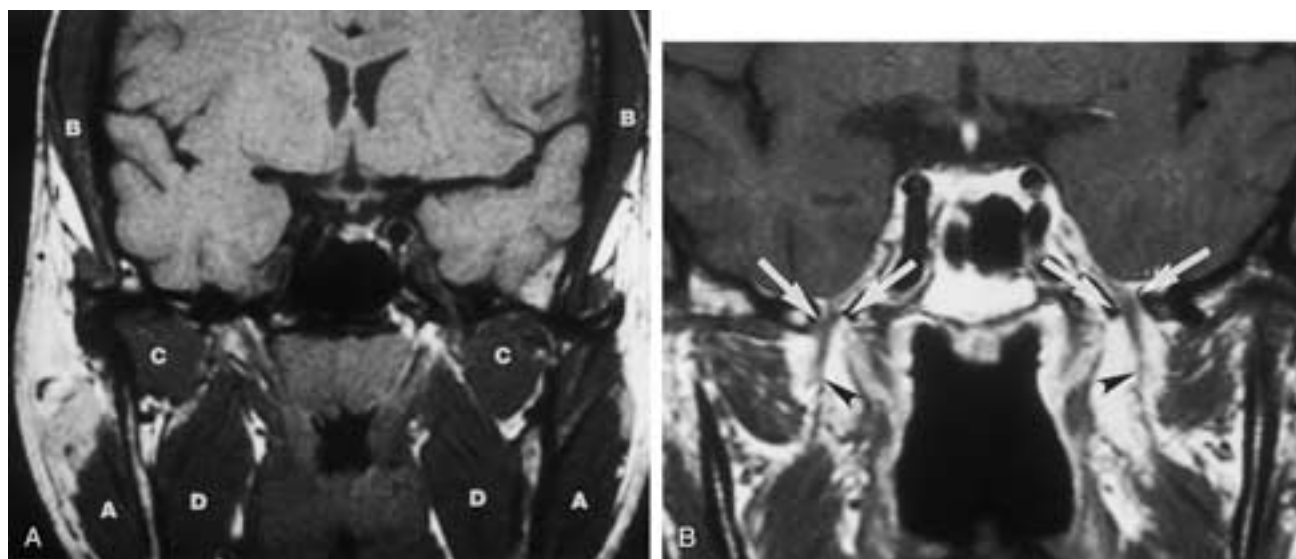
Masticator space, normal anatomy. A, Coronal T1-weighted MR image demonstrates normal muscles of mastication bilaterally. A, Masseter muscles; B, temporalis muscles; C, lateral pterygoid muscles; D, medial pterygoid muscles. B, Coronal T1-weighted MR image following contrast administration optimally demonstrates the mandibular nerves bilaterally (arrowheads) as they traverse the foramen ovale bilaterally (arrows).
